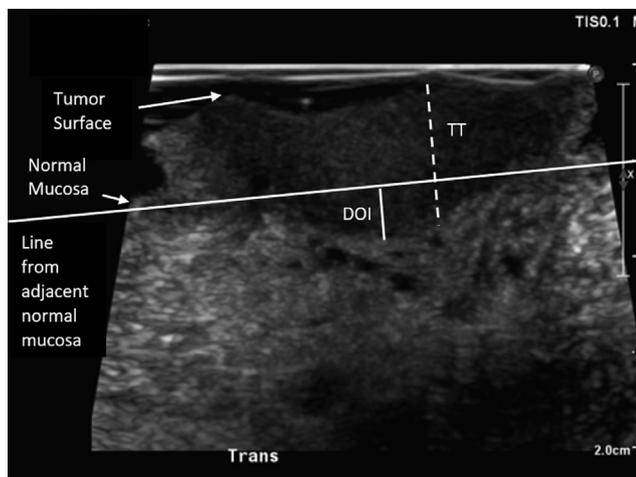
Ultrasonographic image of an exophytic oral tongue tumor showing the discrepancy between DOI (vertical solid line) and TT (vertical dashed line). A DOI of 2 mm and TT of 6 mm was reported on final pathology.
